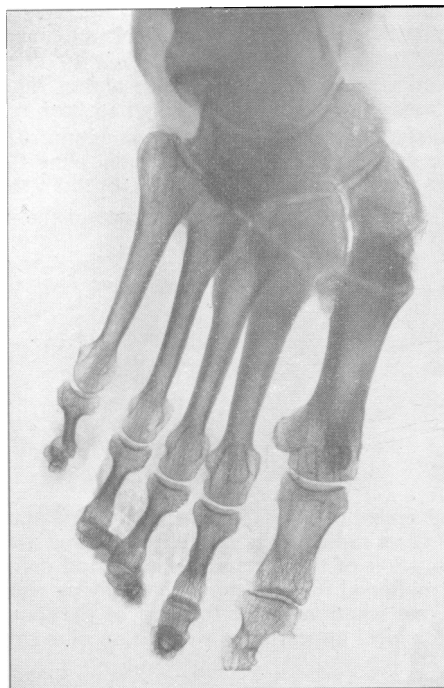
Radiograph of the right foot showing deformity of the tarsus with proximal displacement of the lateral metatarsals. The medial three tarsometatarsal joints show a severe arthropathy with considerable destruction of subarticular bone. There is no evidence of osteoporosis.
